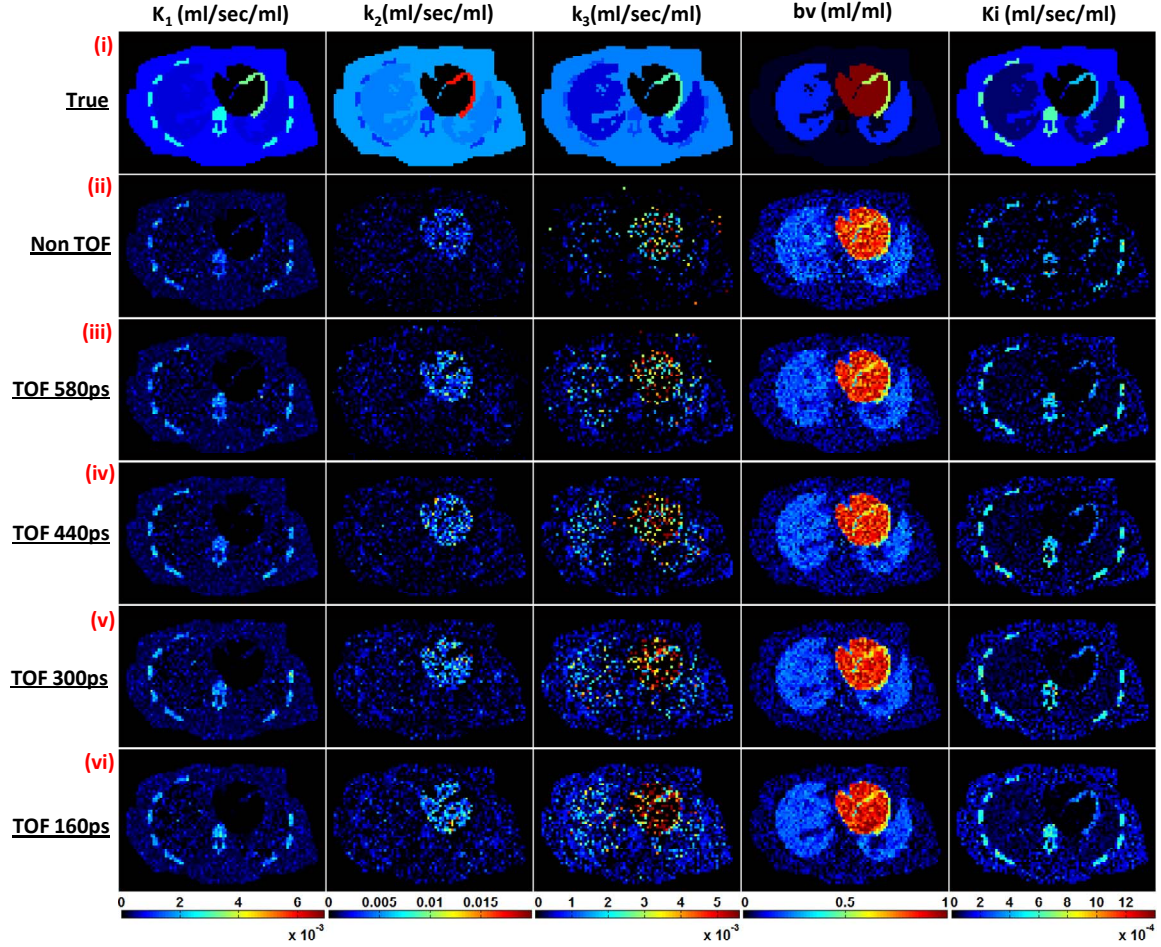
True (i) and estimated [^{18}F]FDG parametric maps using traditional post-reconstruction kinetic analysis at various TOF resolutions (iii-vi).
